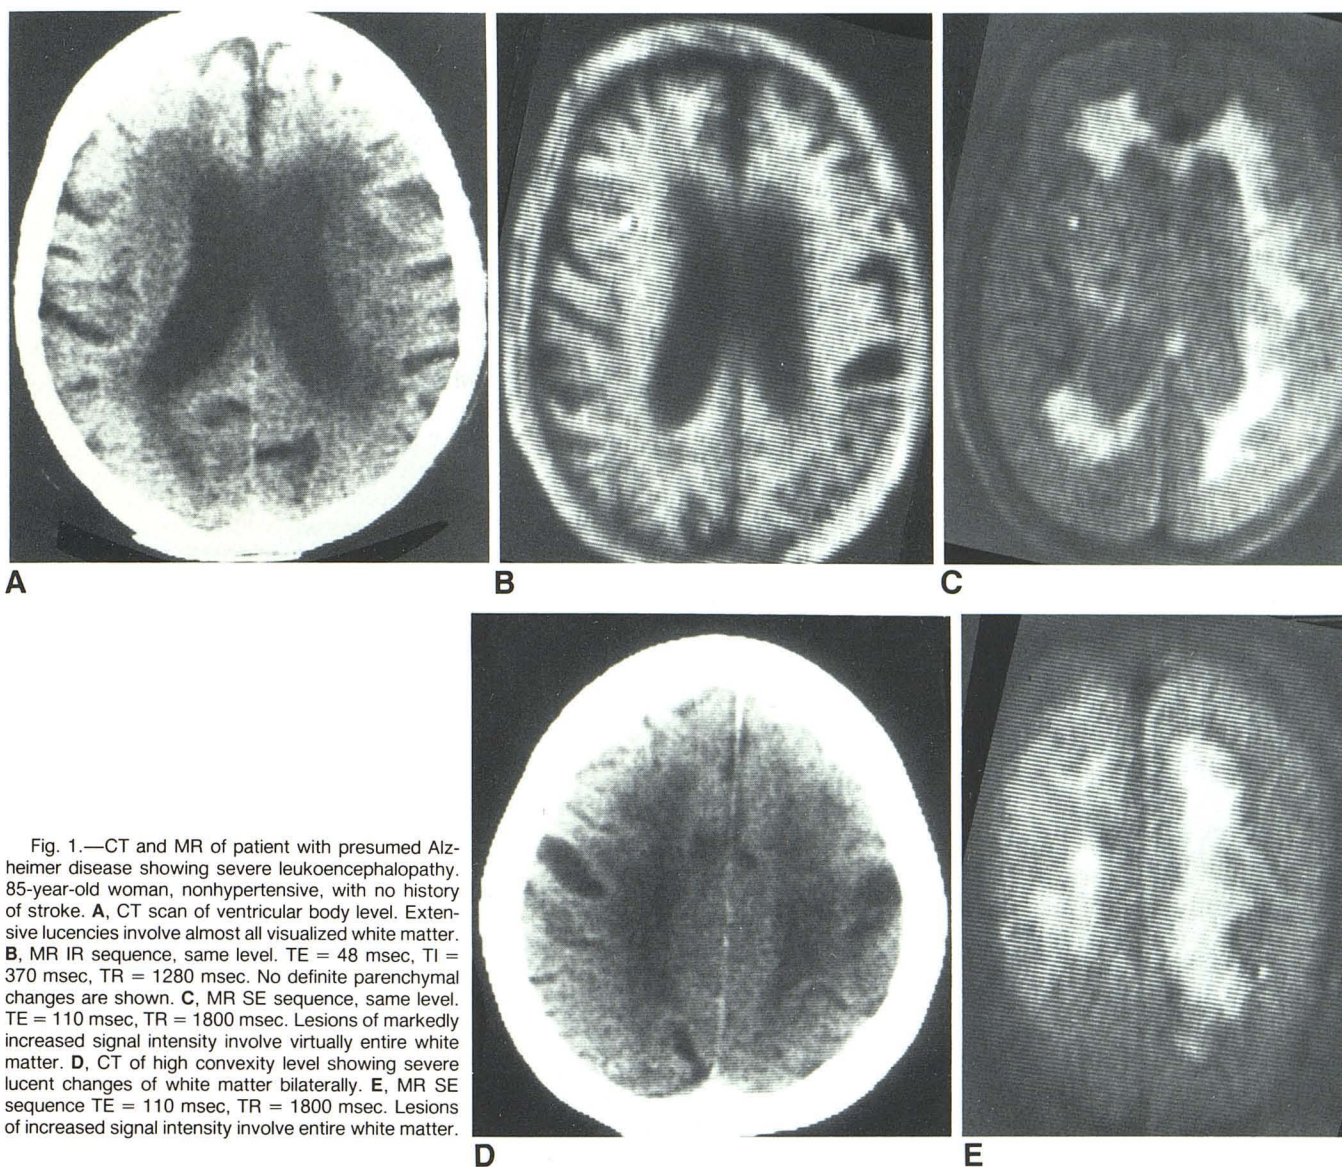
CT and MR of patient with presumed Alzheimer disease showing severe leukoencephalopathy. 85-year-old woman, nonhypertensive, with no history of stroke. A, CT scan of ventricular body level. Extensive lucencies involve almost all visualized white matter. B, MR IR sequence, same level. TE = 48 msec, TI = 370 msec, TR = 1280 msec. No definite parenchymal changes are shown. C, MR SE sequence, same level. TE = 110 msec, TR = 1800 msec. Lesions of markedly increased signal intensity involve virtually entire white matter. D, CT of high convexity level showing severe lucent changes of white matter bilaterally. E, MR SE sequence TE = 110 msec, TR = 1800 msec. Lesions of increased signal intensity involve entire white matter.
